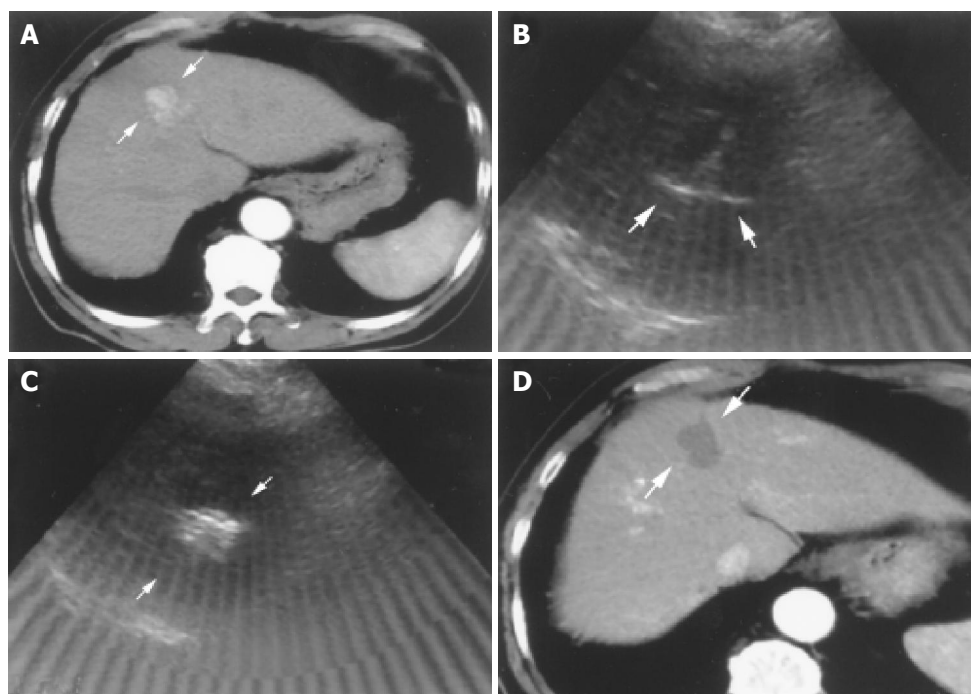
Successful RFA in an 82-year-old male patient with HCC. A: Tri-phase CT scan showed an enhanced nodule in hepatic arterial phase about 2.8 cm in size before RFA (arrows); B: Radiofrequency ablation was performed in one session. The needle was introduced into the lower part of the tumor first with fully expanded tines under real-time ultrasound-guidance (arrows); C: Complete ablation after 2 ablative courses within 37 min was done. The tumor showed hyperechoic signals after RFA under ultrasound (arrows); D: Tri-phase CT scan showed complete necrosis of this tumor without enhancement in hepatic arterial phase one month after RFA (arrows).
